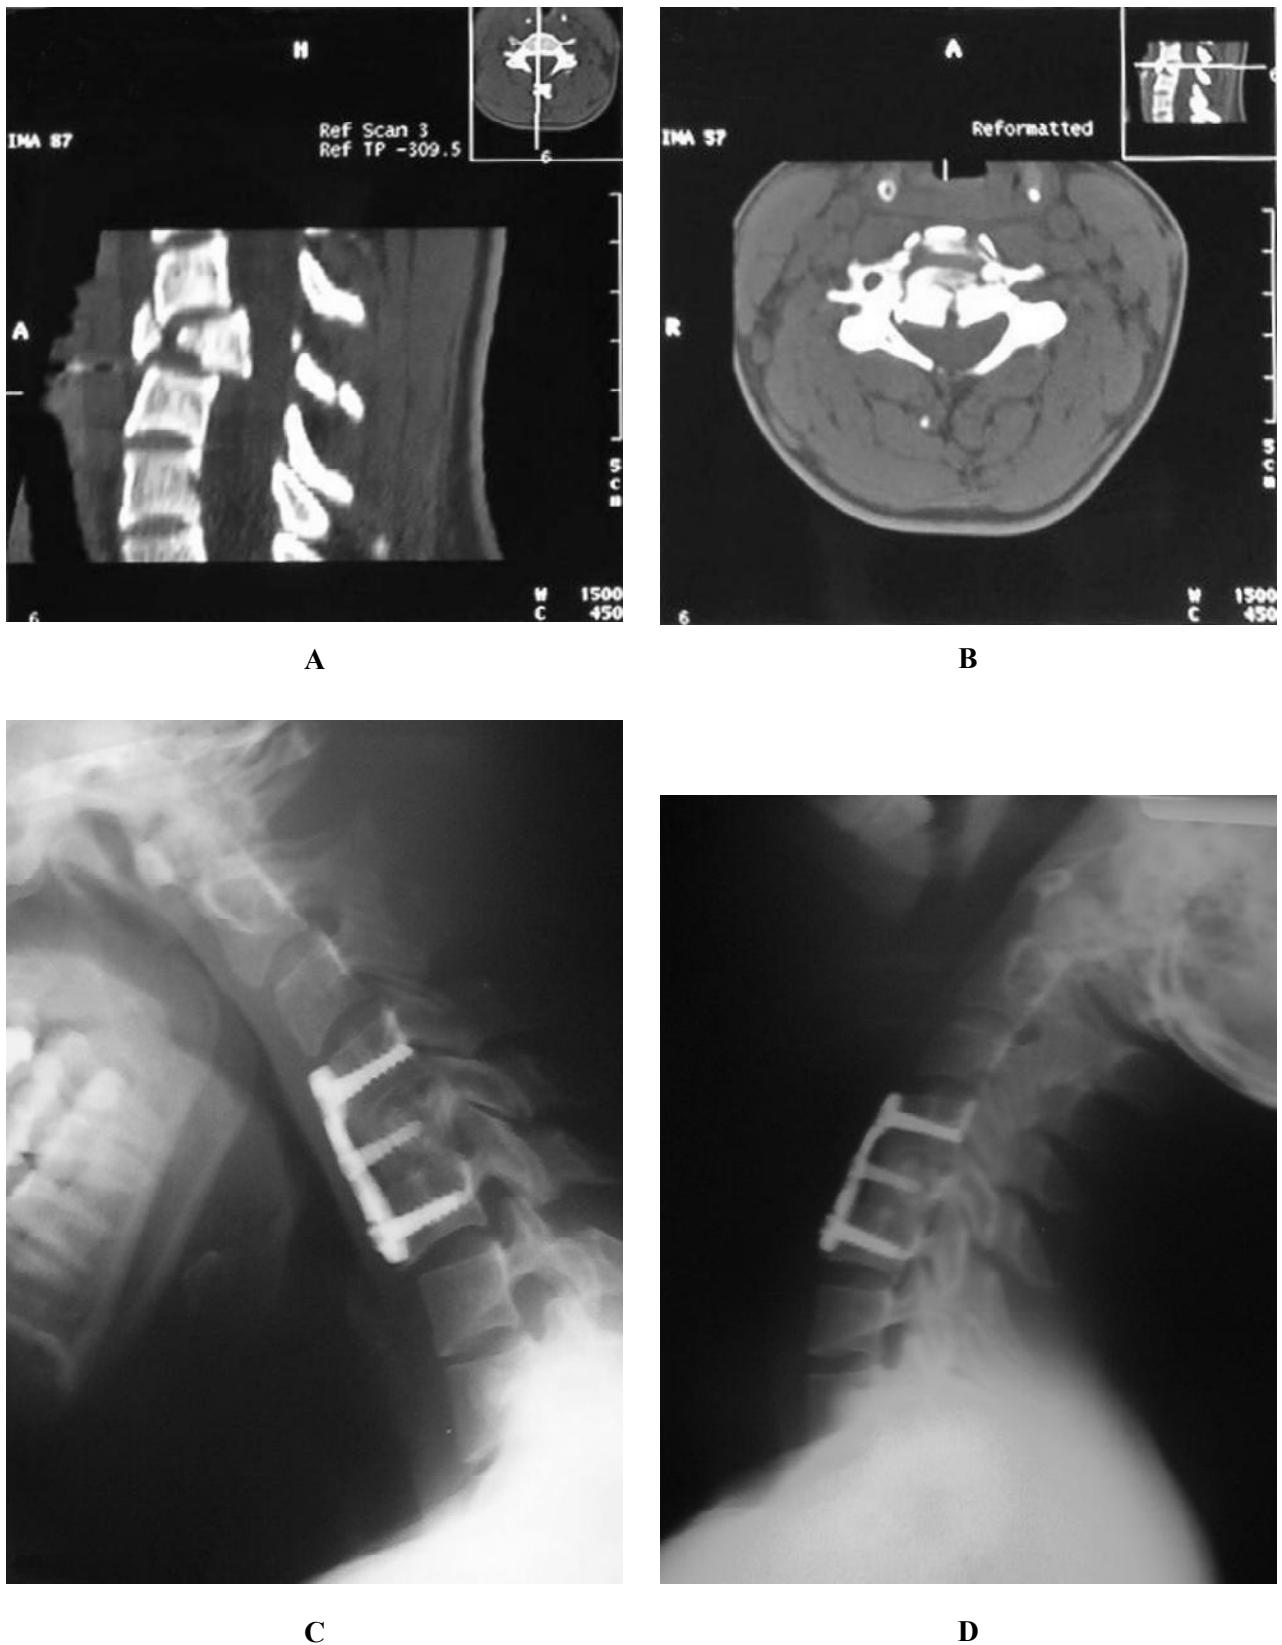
Radiographs of a 20-year-old patient
